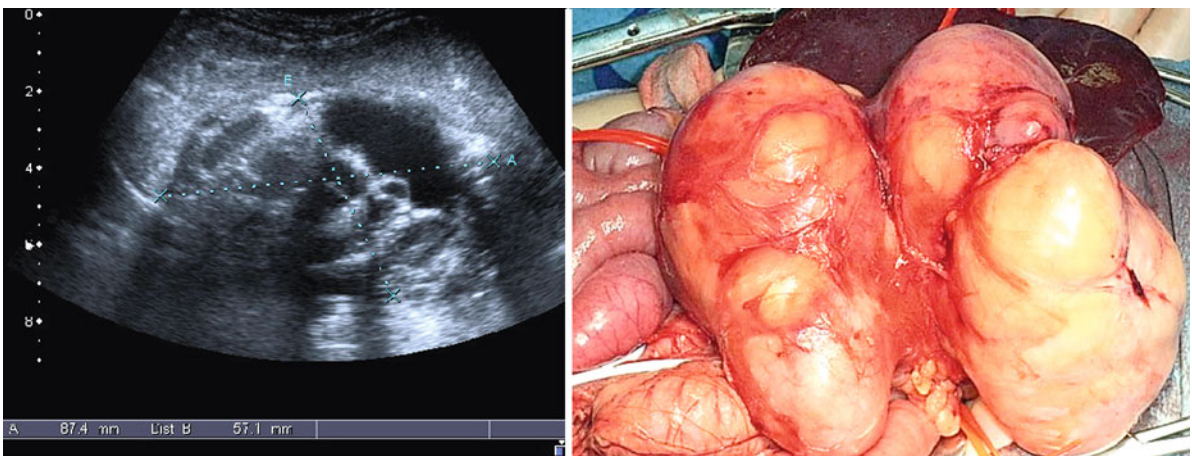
Retroperitoneal teratoma in a 1-year-old girl: ultrasound and operative situs
